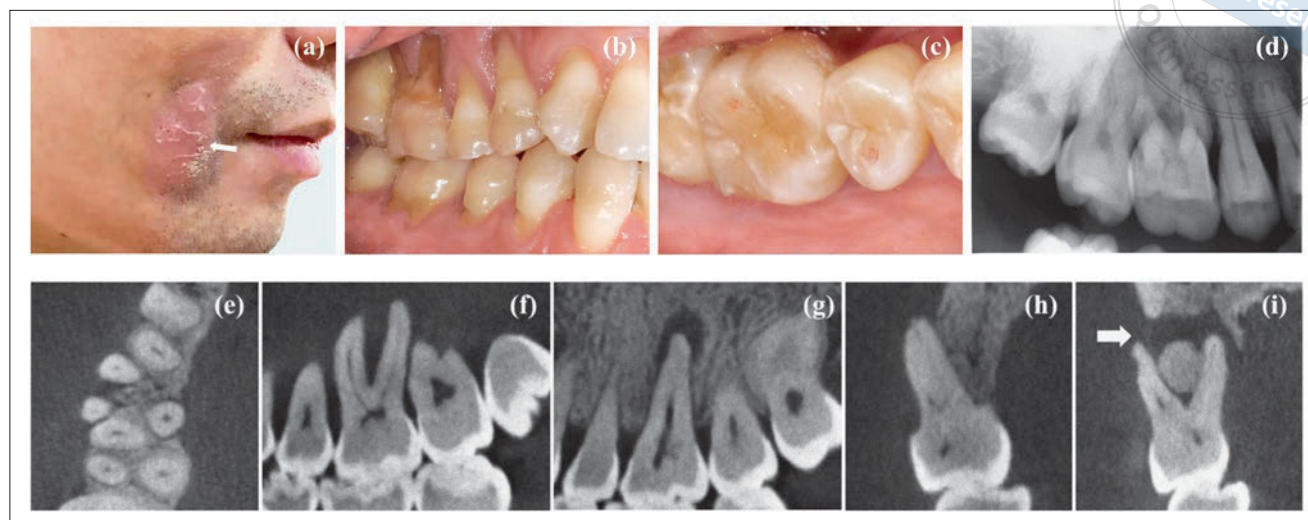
to i Preoperative clinical presentation and radiographic examination. An erythematous sinus tract at the right cheek. The white arrow indicates the location of drainage (a). Intraoral examination showed a poorly distributed occlusal force and extensive gingival recession of the maxillary right first molar (b and c). The preoperative periapical radiographic examination indicated periapical lesion of tooth 16 (d). Periapical lesions were found for the mesiobuccal root, distobuccal root and palatal root on CBCT scans, which revealed signs of bone dehiscence in the buccal alveolar bone (e to i).
